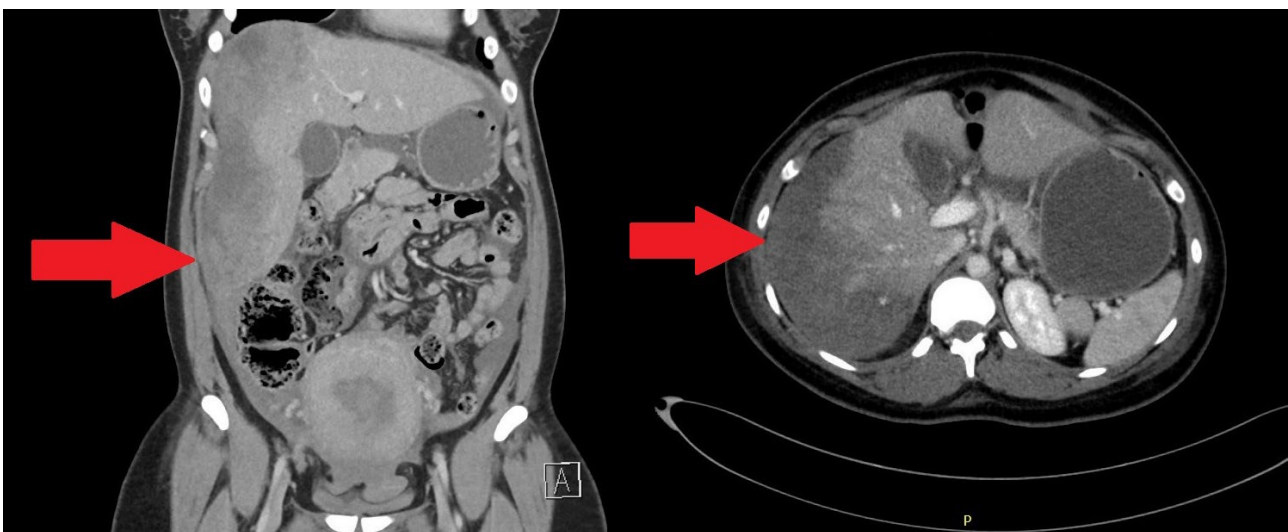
CT radiography of the patient's abdomen, arrow pointing to hepatic hematoma.
